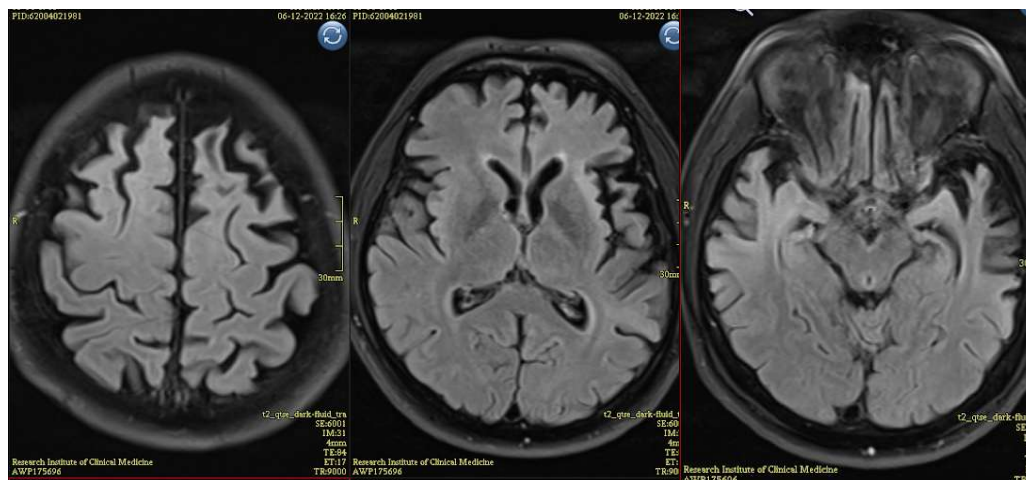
MRI Findings (2022): Progressive Atrophy in the Left Temporal and Frontal Lobe
